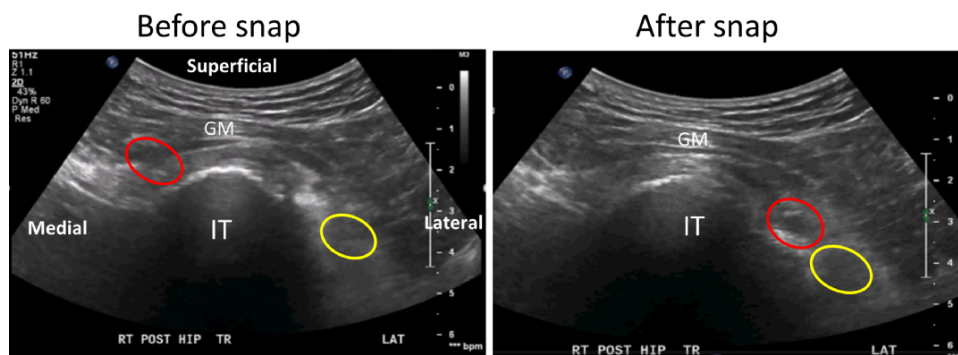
Ultrasound images demonstrating subluxation of the conjoint tendon over the ischial tuberosity. The STL can be seen encircled more medially and superficially than the sciatic nerve (bottom right) before and after snapping. The gluteus maximus (GM) and ischial tuberosity (IT) are also visualized. Note that the superficial probe placement is at the top of the image.
